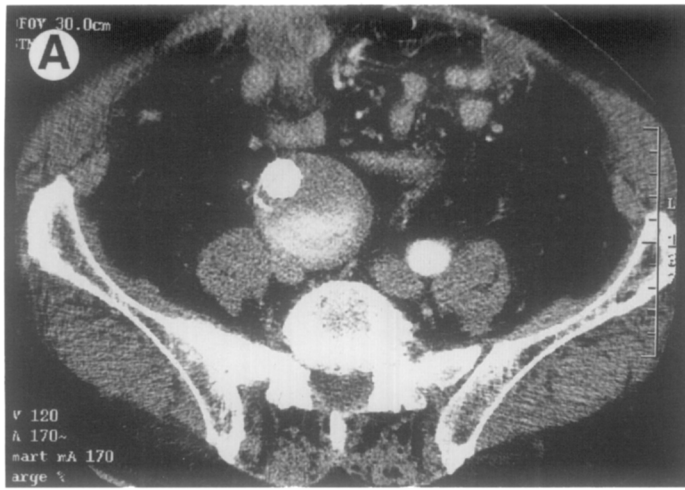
Pseudoleak. Contrast-enhanced CT scan (A) through the pelvis shows a possible endoleak within the posterior aneurysm sac. On the noncontrast CT scan (B) at the same level, there is a similar collection of contrast in terms of shape, size, and location. This represents residual contrast from the previous day's contrast angiogram performed during the stent-graft implantation procedure. This does not represent an endoleak.
